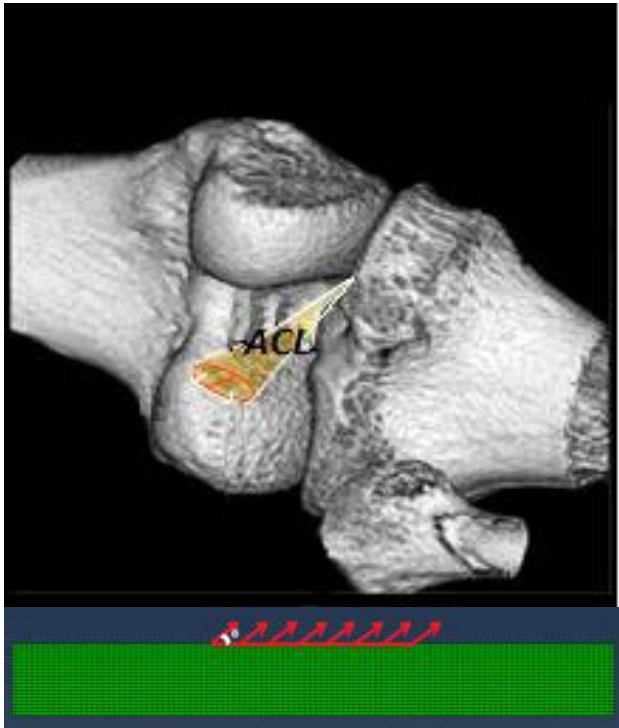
3-D CT image of the human knee including the femoral attachment of the ACL and 2-D model of the femoral cortical bone with the ACL force applied to the ACL attachment area.
